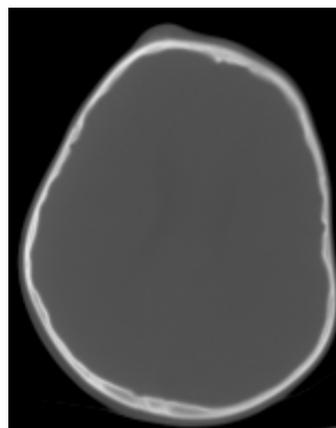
Skull CT-scan of this patient indicating soft tissue mass(75-95 HU in density) without bone formation and calcification in the right frontal convexity.
